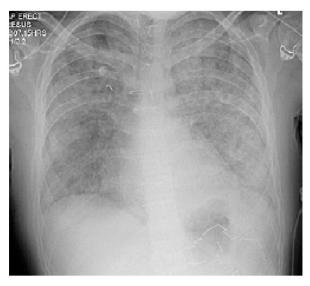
Chest radiograph showing acute pulmonary haemorrhage
